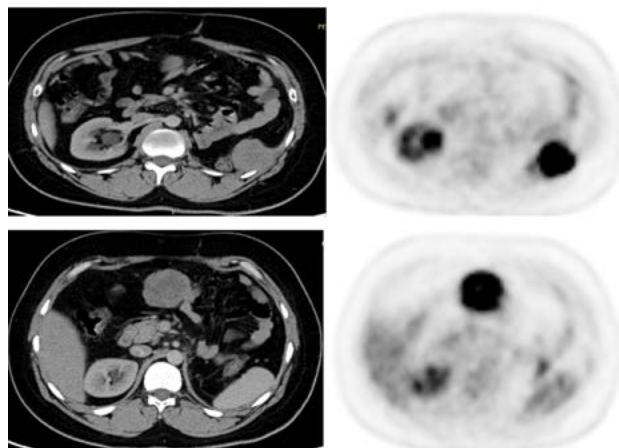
38-years-old male patient underwent left nephrectomy for RCC, FDG PET-CT revealed FDG avid recurrent soft tissue mass at the operative bed SUVmax ~12.2, as well as large peritoneal deposit SUVmax ~10.2
